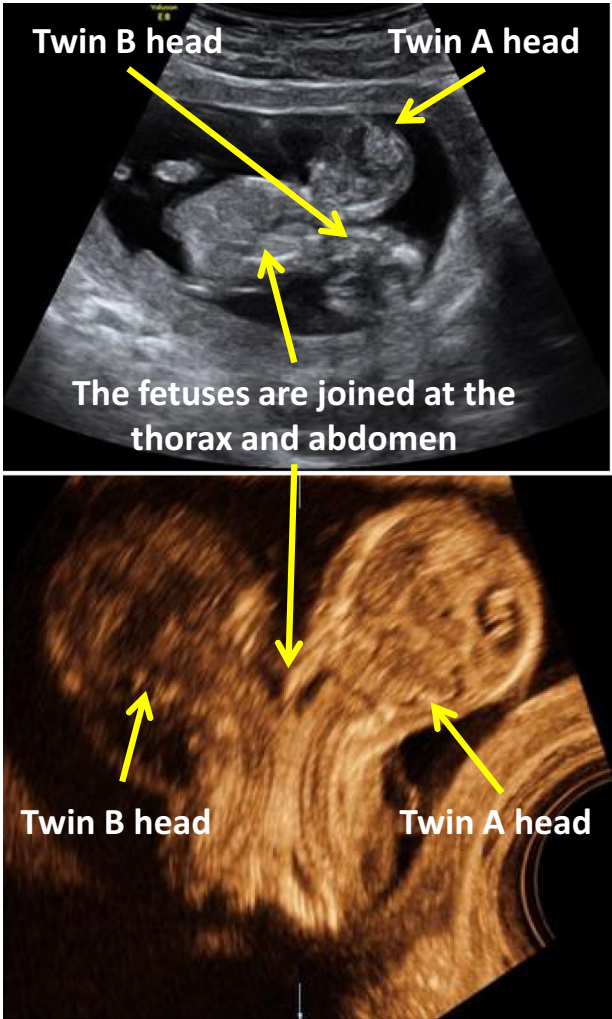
Ultrasound (2D upper image; 3D lower image) of conjoined twins at 12+5 weeks (Thanks to Professor Rabih Chaoui, Berlin).
